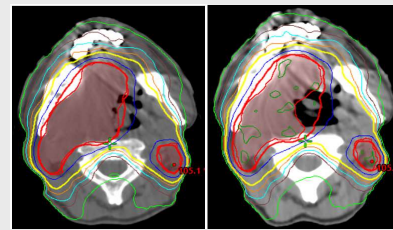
pCT and deformed CBCT
